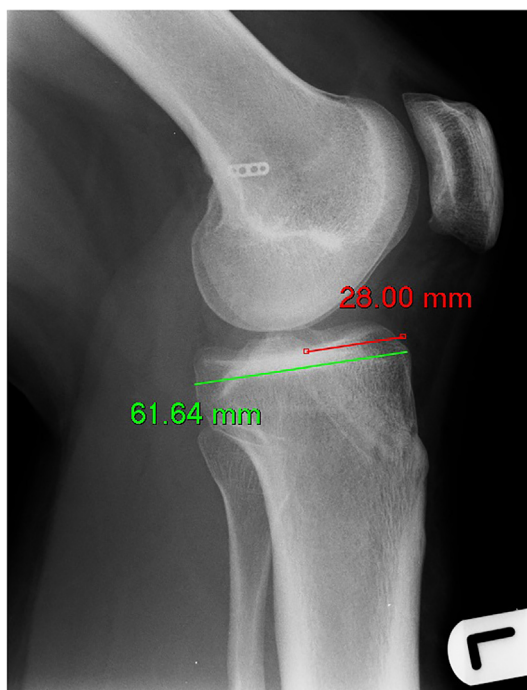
Lateral radiograph of the knee showing method of measuring tunnel position. Red line: distance of tibial tunnel from anterior aspect of tibia, Green line: depth of tibial plateau. Anterior to posterior tunnel position = 45.4%.
